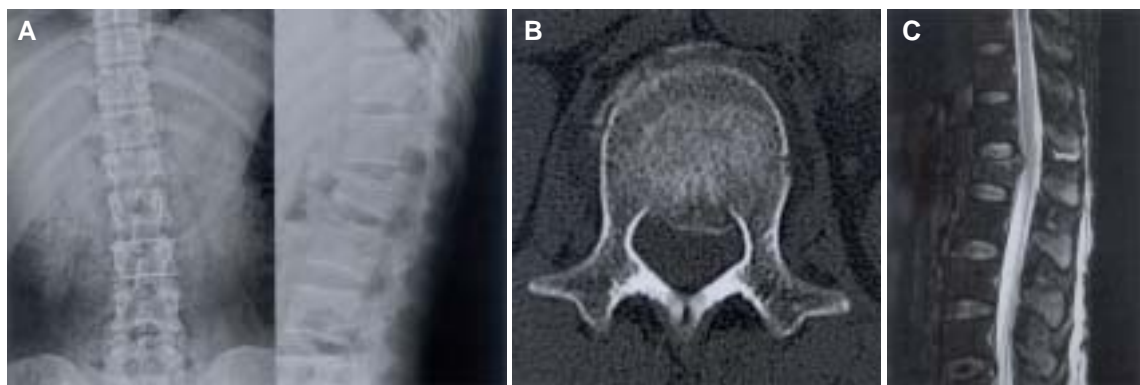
Radiography of a 47-year-old woman show burst fracture of L1 (A). Canal encroachment is about 20% on CT scan (B). Fat-suppressed T2-weighted sagittal sequence of MR imaging shows disruption of supra spinatus and interspinous ligament (C).
